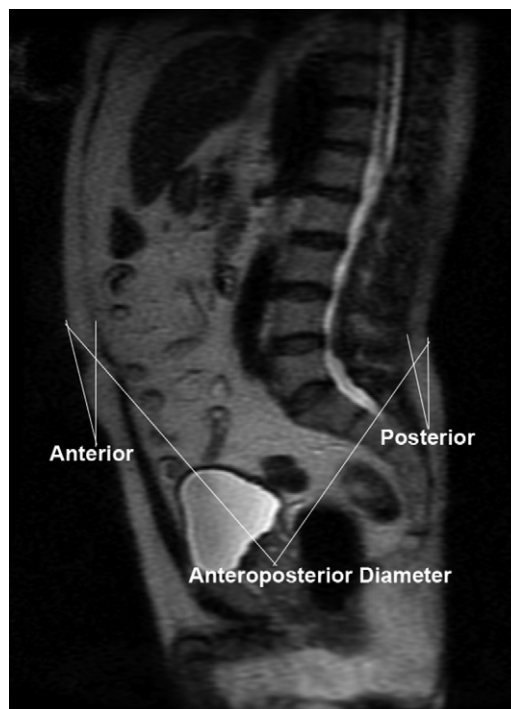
Representation of the T2 weighted sagittal localization images obtained on endorectal coil MRI. The largest anterior, posterior, and total anteroposterior diameter were obtained in 3 images around the midline and the results were averaged.
